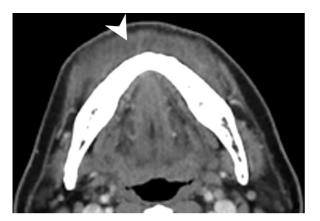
Computed tomography scan showing diffuse soft tissue swelling of the subcutaneous layer (arrow head) over the entire lower lip and cheek.
